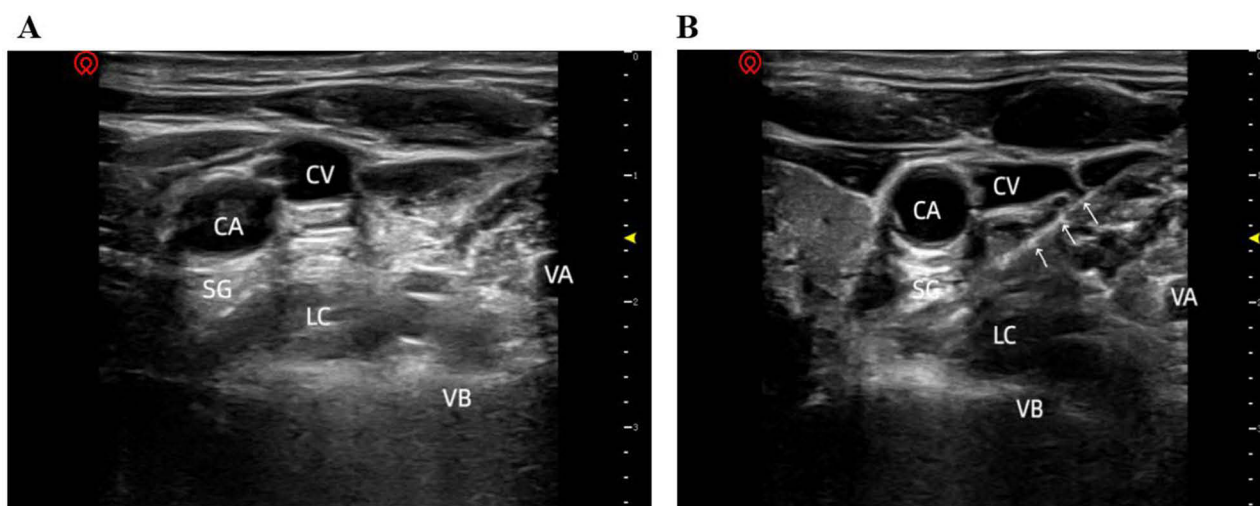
Ultrasound guided image of SG. The structure of continuously strongly echoing lumpiness on the surface of the longus cervicalis muscle between C7 to T1 levels (A). Ultrasound image of needle tip insertion site was placed in the structure of continuously strongly echoing lumpiness, on the surface of longus colli muscle, under the prevertebral fascia. White arrow indicates where needle is located (B).
